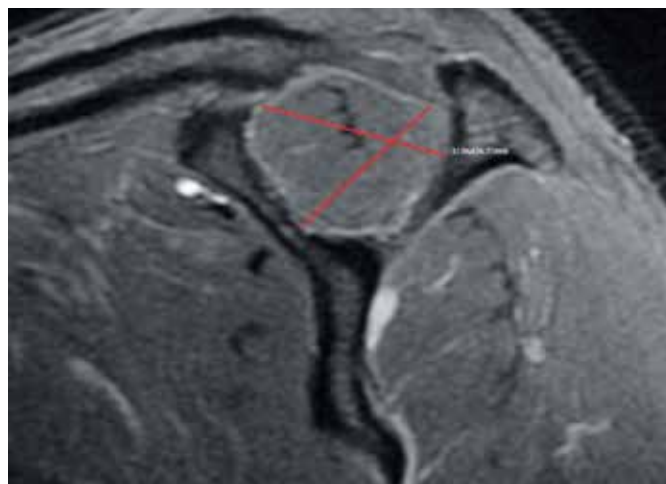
Measurement method of supraspinatus muscle volume via MRI.
